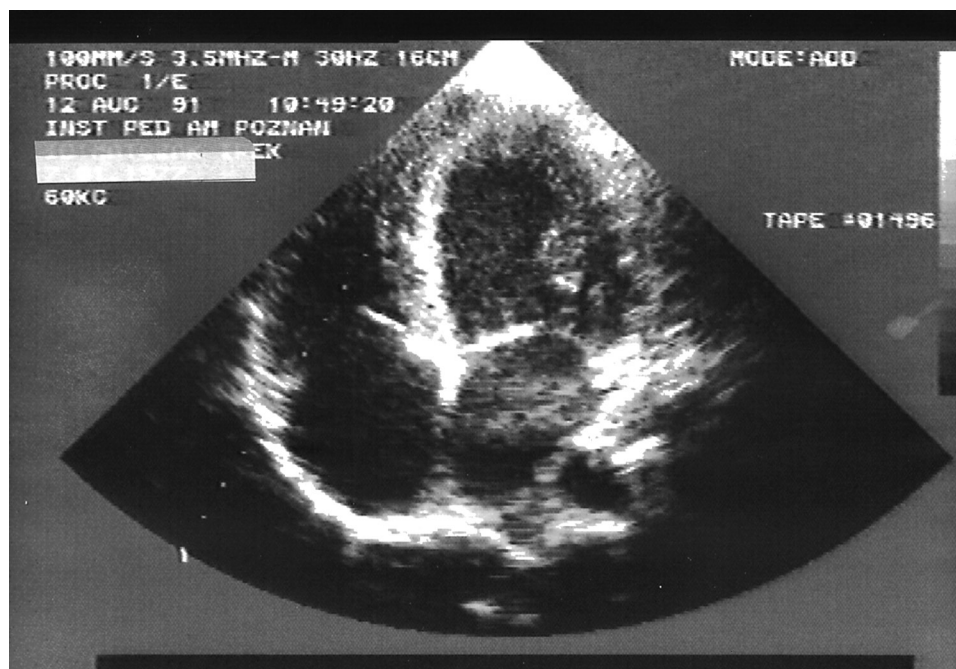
Echocardiography. Left ventricular hypertrophy
